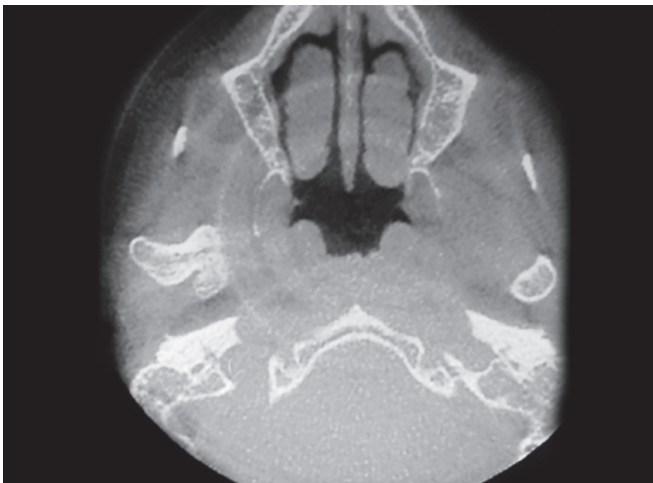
Axial section of CT showing disfigured head of the right condyle
